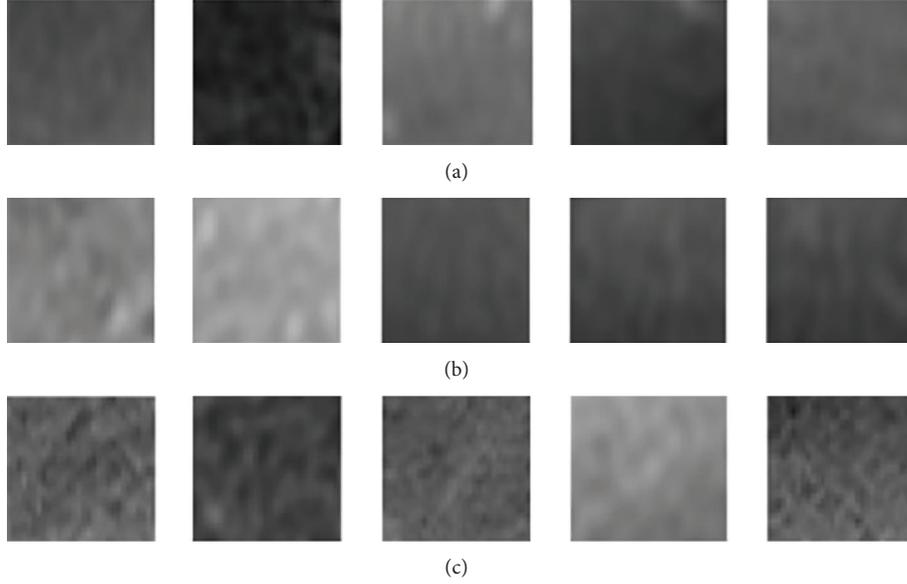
Normal, early, and middle and advanced stage ROIs form T1-weighted, T2-weighted, arterial phase, portal venous phase, and equilibrium phase.
